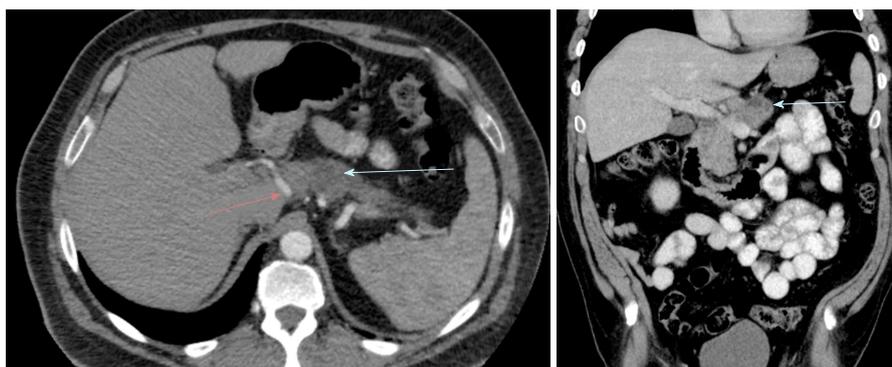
Axial and coronal plane view on computed tomography of a patient with a 2 cm mass in the body of pancreas (blue arrow), abutting splenic artery (red arrow).
